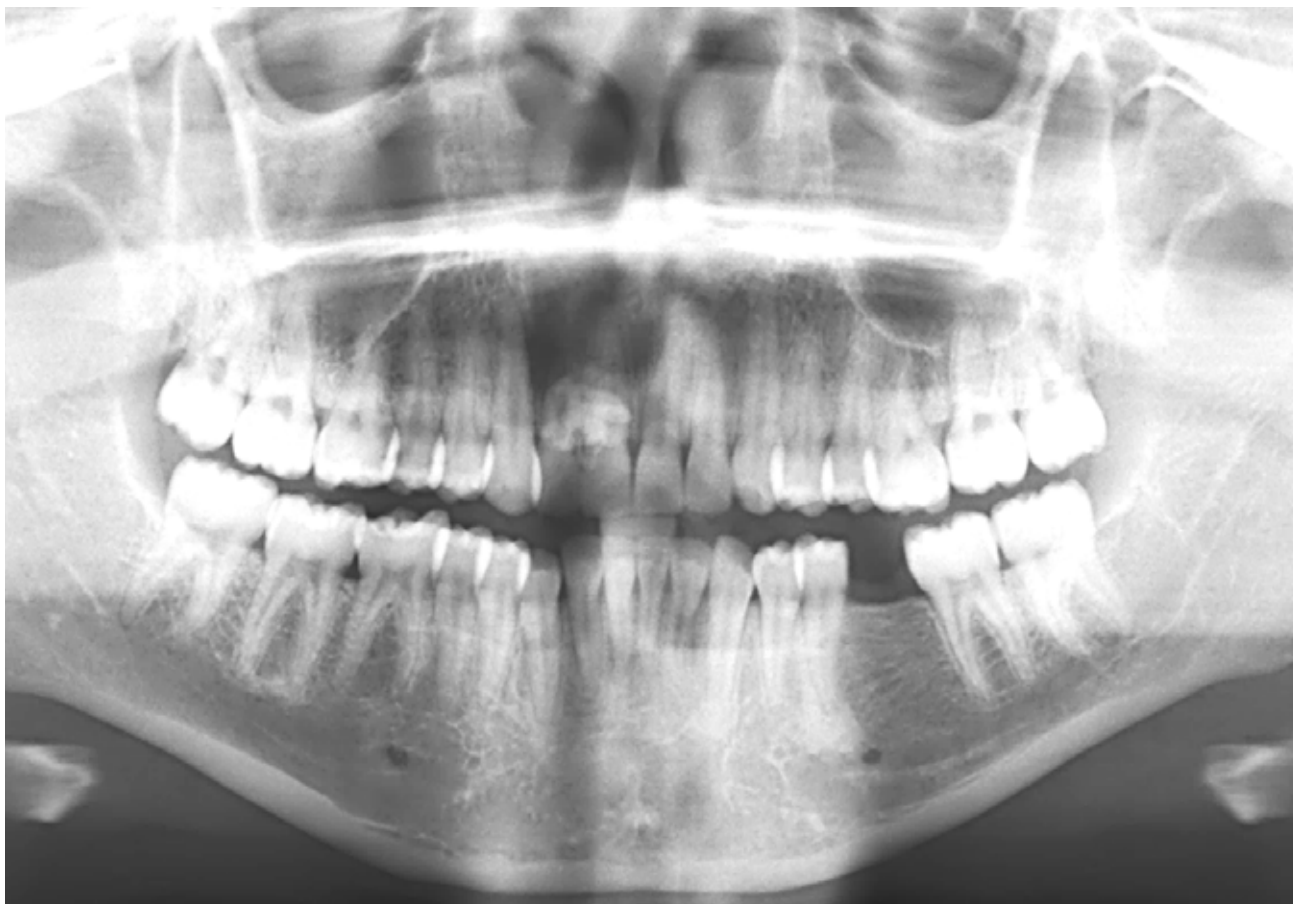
Panoramic radiograph showing the superimposition of an erupted compound odontoma on the palatal aspects of the roots and crowns of tooth 11 and tooth 12.
